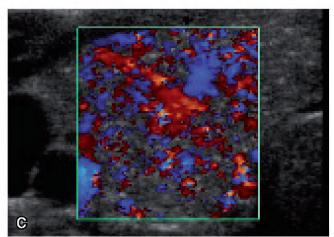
Ultrasound of papillary thyroid carcinoma in the right lobe and isthmus. A and B, Transverse. C, Color Doppler, transverse.
